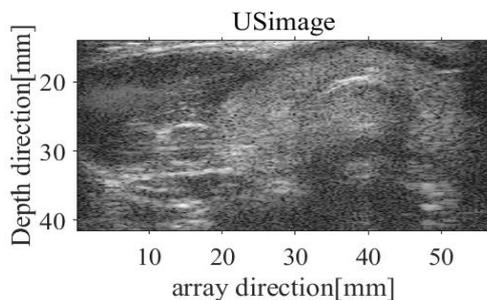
Ultrasonic image of the human neck.
